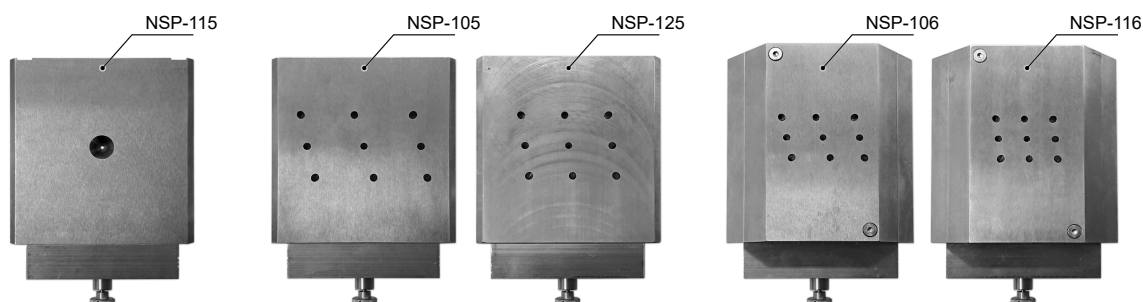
Pinhole collimators of the NanoSPECT/CT<sup>plus</sup> system.
